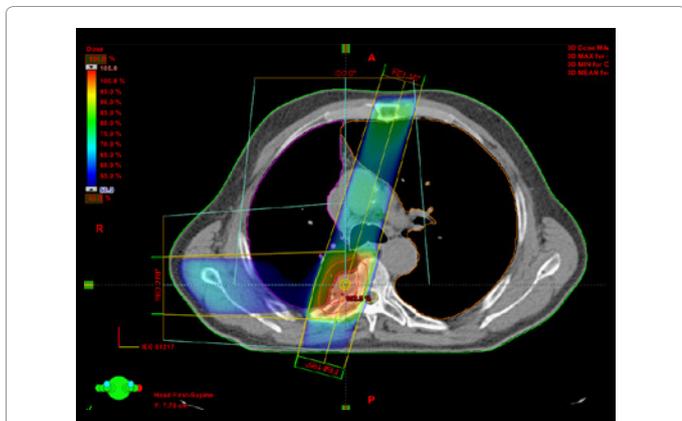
Treatment planning CT scan showing the dose distribution during initial radio- and chemotherapy (total dose to the ICRU reference point 59.4 Gy, dose per fraction 1.8 Gy). Clinical target volume and planning target volume are displayed. They received at least 95% of the reference dose. The treatment planning system was Eclipse by Varian Inc.
